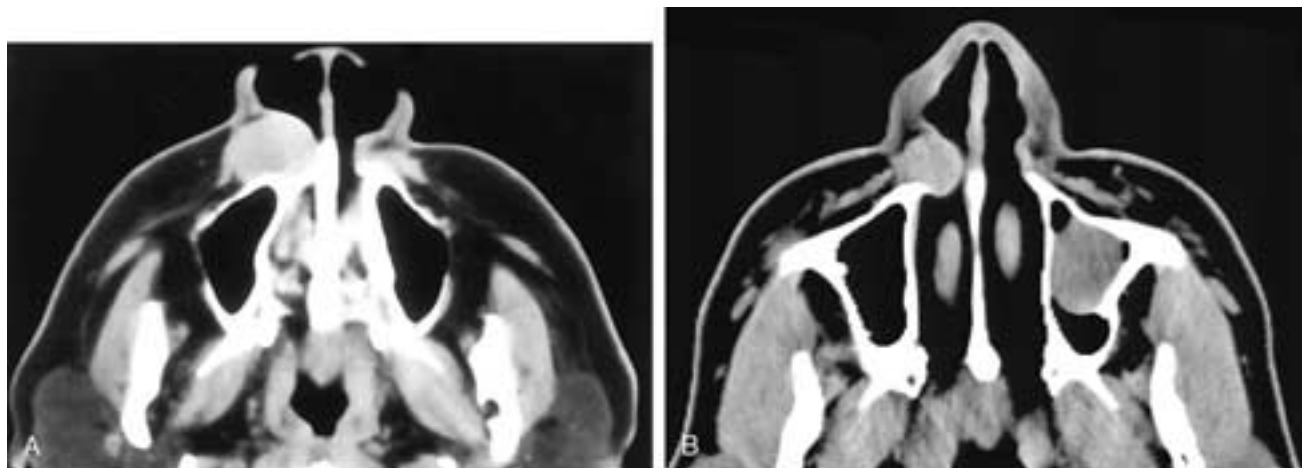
Axial CT scan (A) shows a soft-tissue density ovoid mass in the soft tissues of the right face deep to the lateral margin of the nose. The adjacent maxillary bone is uninvolved. In B a CT scan on another patient shows an ovoid mass in the lateral nostril region anterior to the medial maxilla. The bone is not involved. An incidental retention or polyp is present in the left antrum. Both of these patients had nasoalveolar cysts.
